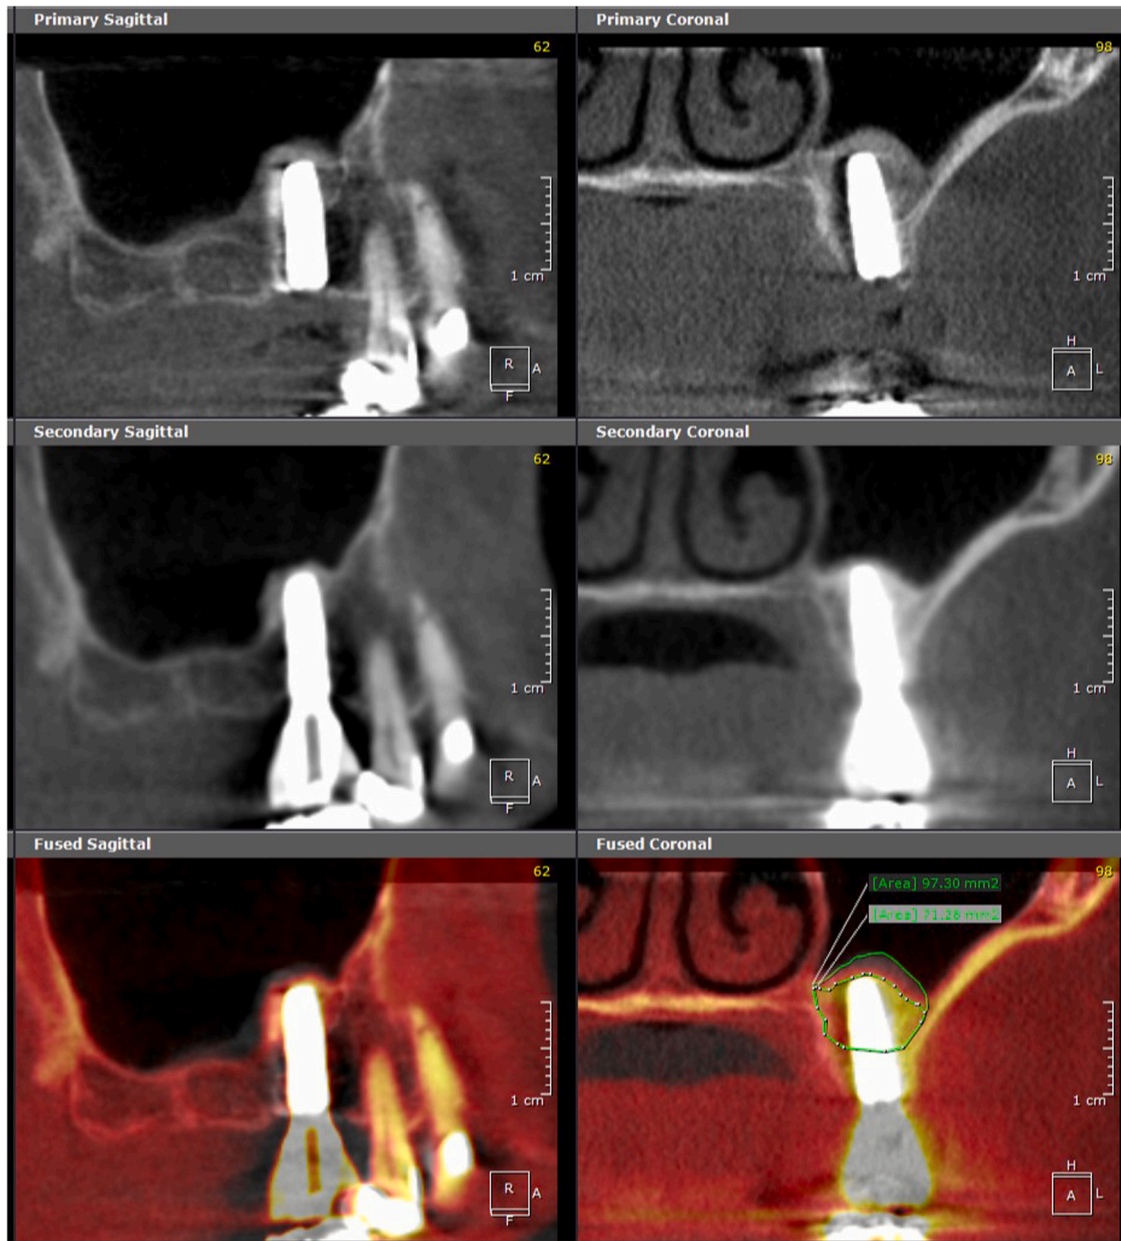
Cone beam computed tomography scans obtained immediately after osteotome-mediated sinus floor augmentation and simultaneous implant placement were superimposed with the scans taken after delivery of the prosthetic rehabilitation. The original border of the maxillary sinus and circumference of the augmented area were outlined before the volume of the grafting material was calculated, at each of the different time periods.
